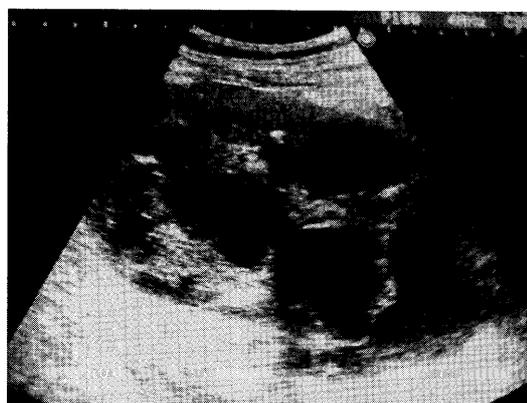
Ultrasound image showing a large cystic mass with multiple separated septa
